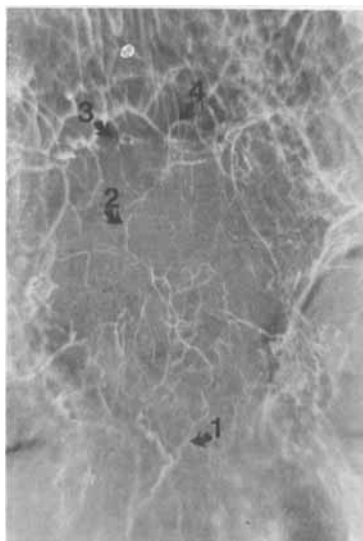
Frontal longitudinal section. Radiograph of Spalteholtz preparation. (cf. Figure 4 b, no. 1; slice thickness 10 mm).
